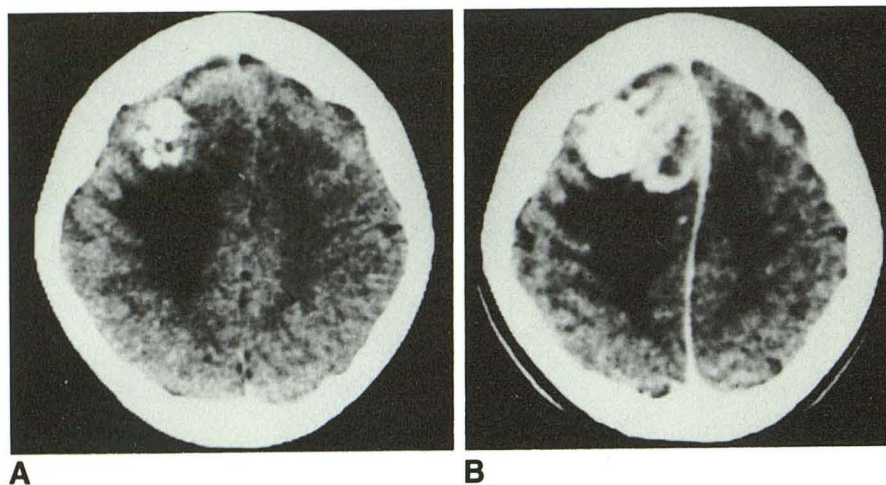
A and B, CT scans of brain without and with contrast show flocculent calcification with contrast enhancement in right frontal vertex with associated edema and bowing of a thickened falx cerebri.
